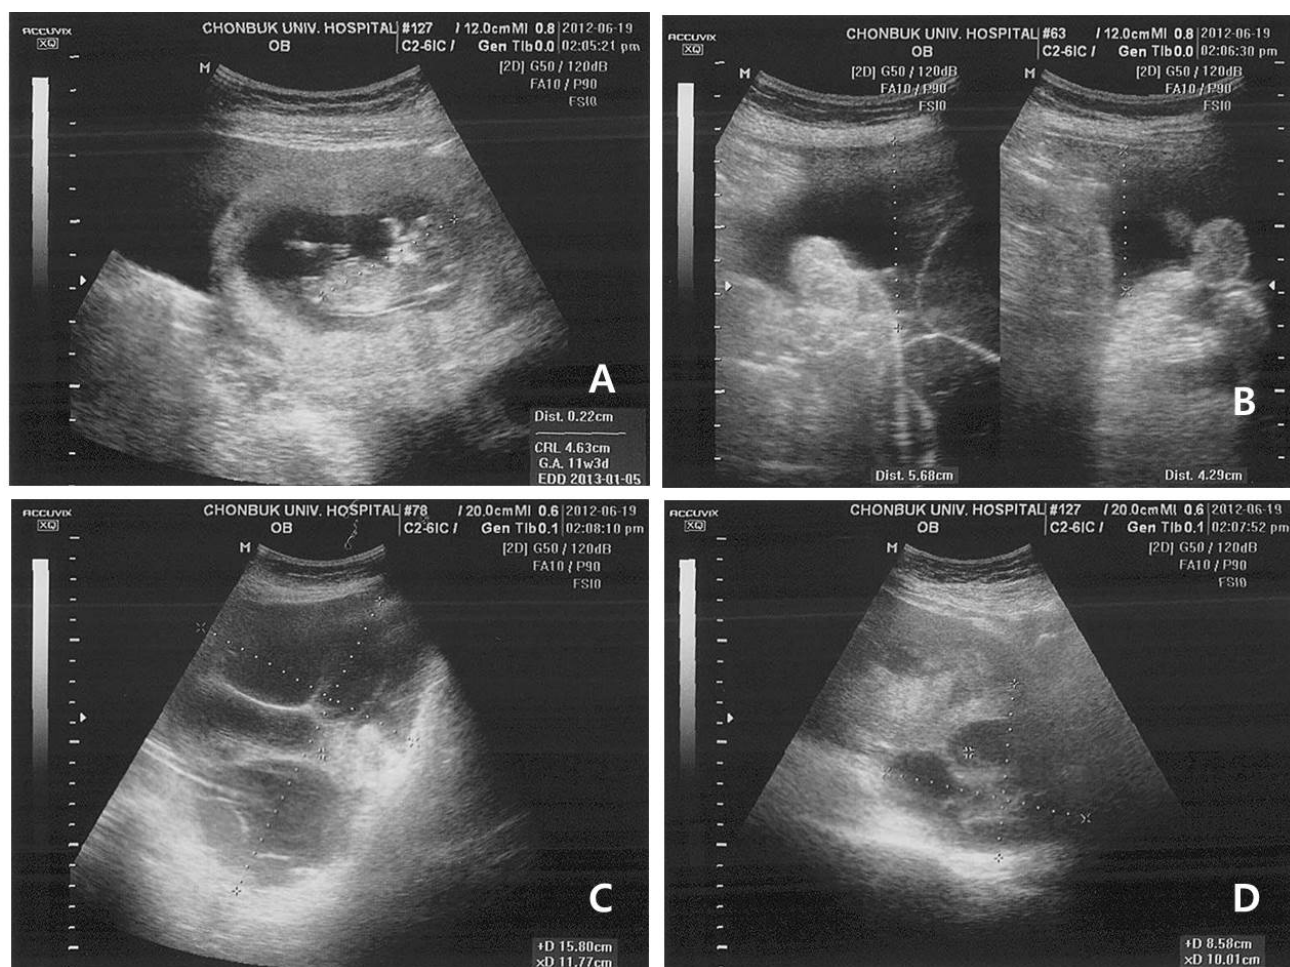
Ultrasonographic findings of hyperreactio luteinalis. (A) uterus containing an 11-week fetus (B) the presence of free fluid in the paracolic gutters (C) enlarged right ovary (D) enlarged left ovary.
